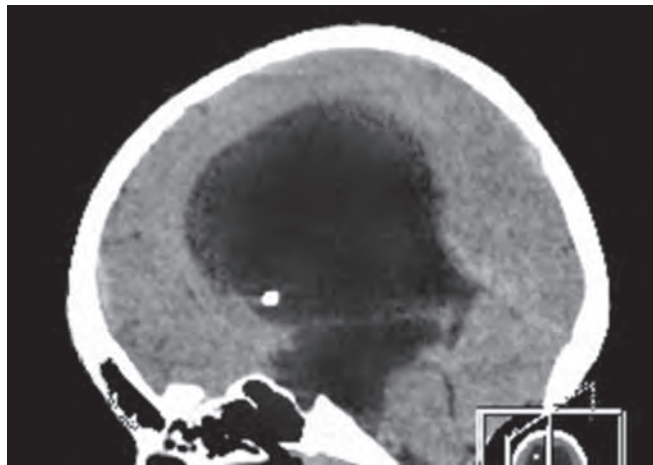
Sagittal reconstruction CT scan of the brain in a patient with aqueductal stenosis
